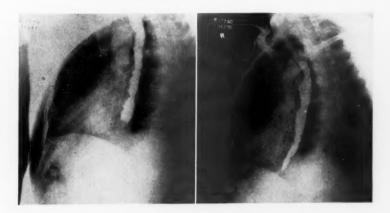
Roentgenogram of Case 10. Obstruction of the lower end of the esophagus is demonstrated by barium. An unusually large amount of barium was used in order to show on the film the hyperactive peristalsis of the esophagus that is best seen fluoroscopically.
